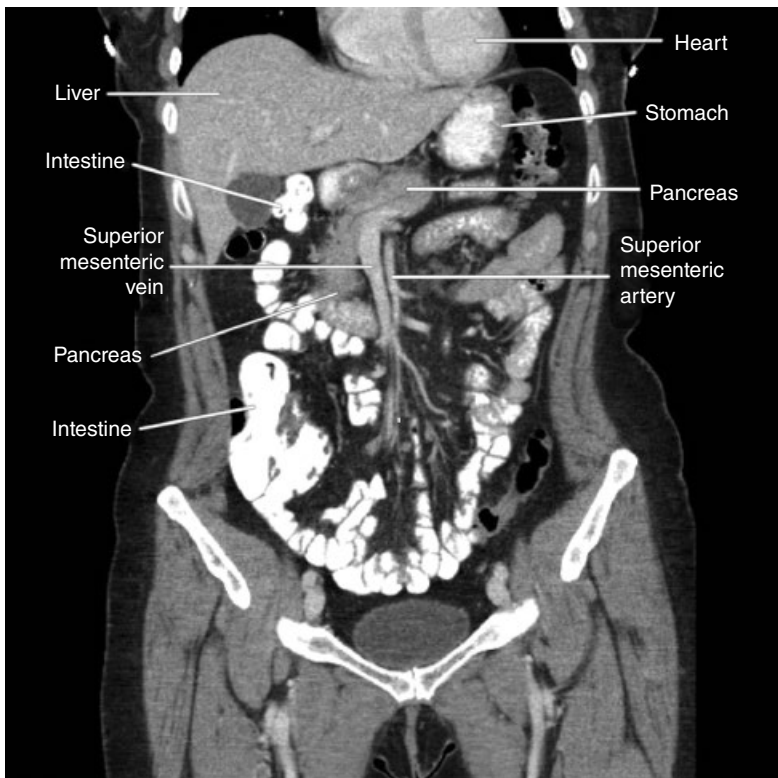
Frontal CT scan in the plane of the head and body of the pancreas. The technology dictates that all structures shown lie in the same plane. The tail of the pancreas is not shown because it lies posterior to the depicted plane. *Source:* Image provided by Jason Ferreira.
